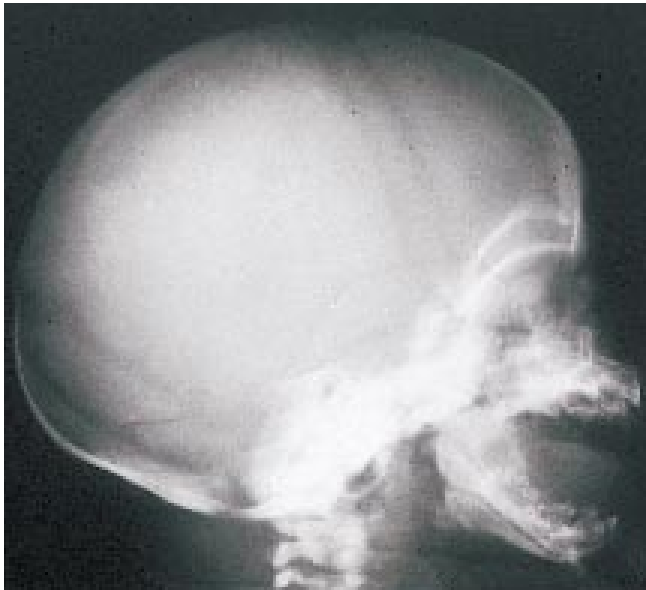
Radiograph of the skull of the same infant showing osteomyelitis of the parietal bone.
